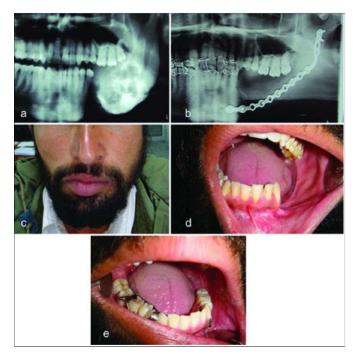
(a) Preoperative rediograph (b) Postoperative radiograph (c) Frontal view 6 months after surgery (d) Inraoral view 6 months after surgery (e) Intraoral photograph after dental rehabilitation.
